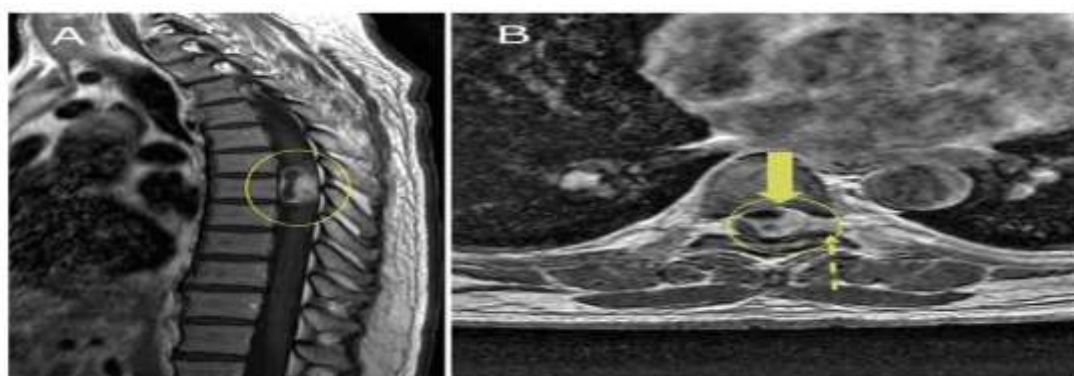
MRI showing intradural extramedullary schwannoma. (A) Sagittal postcontrast T1-weighted MRI of the thoracic spine showing a well-defined enhancing intradural extramedullary lesion at the thoracic level causing compression of the spinal cord (yellow oval). (B) Axial post-contrast T1-weighted MRI at the same level demonstrating intense enhancement of the lesion (solid arrow) with mild lateral extension and compression of the adjacent spinal cord, consistent with schwannoma.
